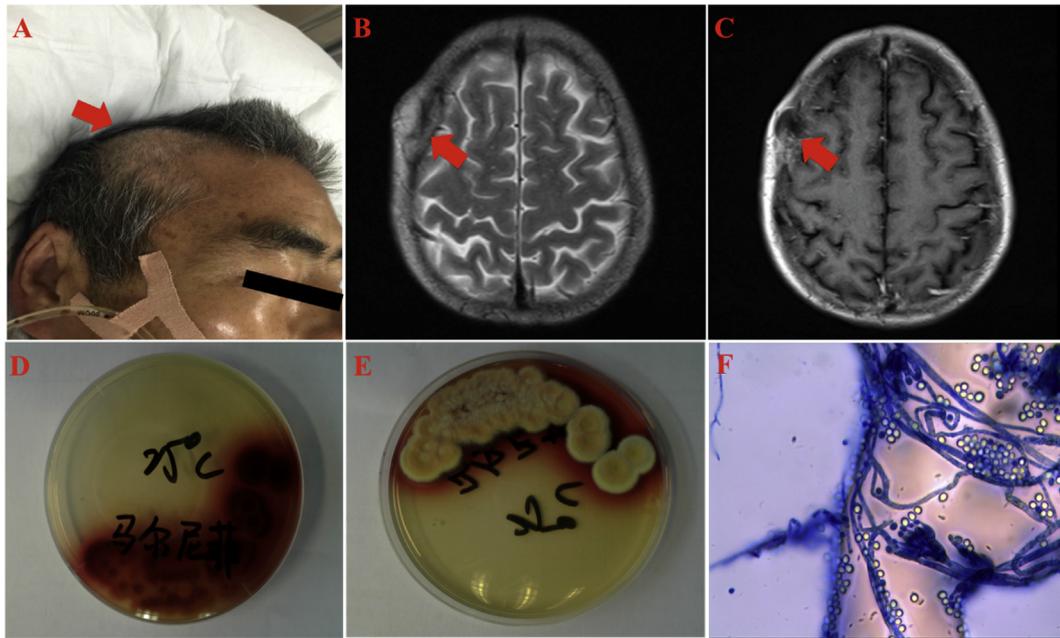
(A) The patient presented with a lump measuring 3×3 cm in the right temple. (B–C) Cranial MRI revealed skull tissue destruction at the site of the lump. (D–F) Culture of bone marrow, blood, sputum, and skull lump puncture fluid revealed *Talaromyces marneffei*, which appeared as sausage-shaped yeast cells with septation. The yeast cells produced red pigment at 25 °C but not 37 °C.
